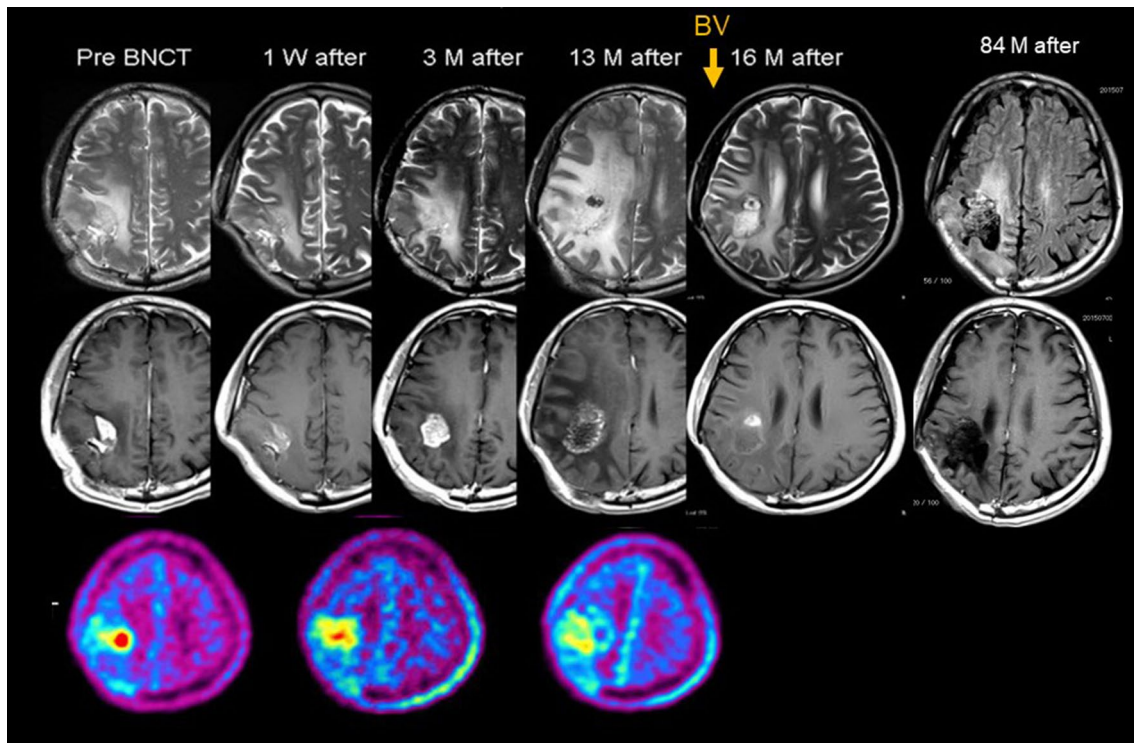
A representative recurrent GBM case treated by BNCT with successive bevacizumab. The right parietal GBM recurred after standard chemo-radiotherapy. The F-BPA-PET image showed marked tracer uptake in the right parietal region with a 3.8 L/N ratio of the tracer, indicating that the lesion was a recurrent GBM. The patient was treated with BNCT. Periodic MRI showed gradual enlargement of both the enhanced lesion and perifocal edema, whereas F-BPA-PET showed a gradual decrease of the tracer uptake. The final L/N
